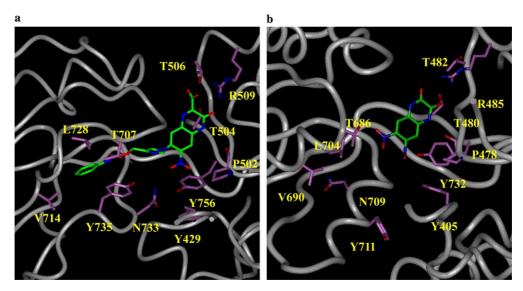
Modeled and X-ray structures of AMPA-R bound to ligands. (a) The bound conformation of 28d in the active site of the modeled AMPA-R. (b) The bound conformation of DNQX in the X-ray structure of AMPA-R active site.
